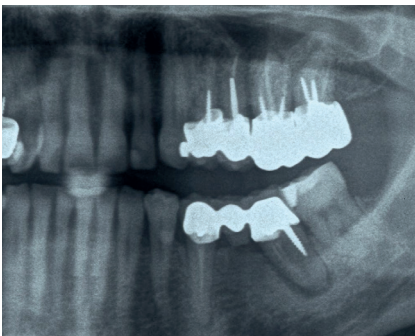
Initial panoramic x-ray showing the mandibular left second molar that has to be extracted.
